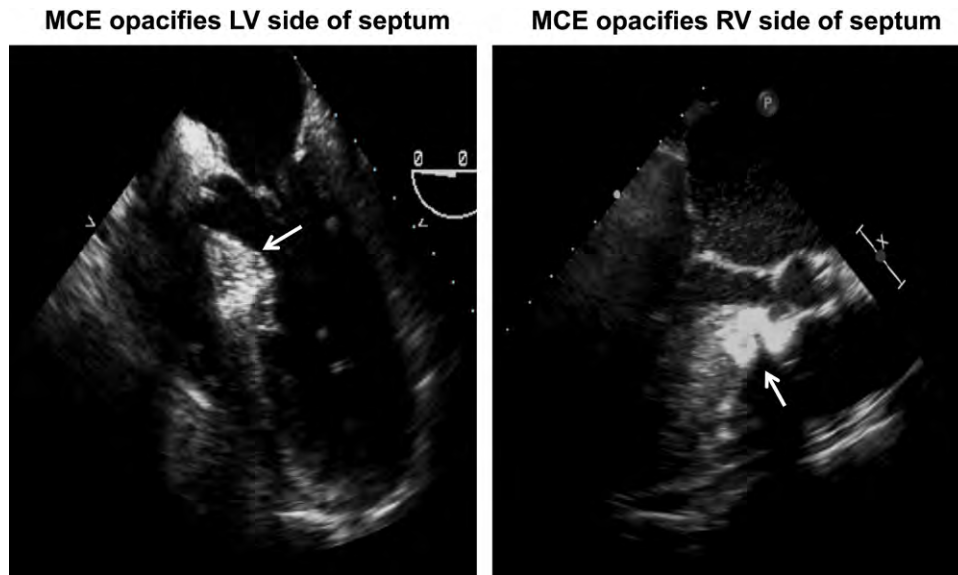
Myocardial contrast echocardiographic (MCE) images from two patients with HCM undergoing alcohol septal ablation. (Left) Opacification of the LV side of the basal septum (arrow), which is involved in the contact with the anterior mitral leaflet and the desired location to induce infarction. (Right) Opacification of the RV side of the septum (arrow), which is not the location that affects dynamic obstruction.
